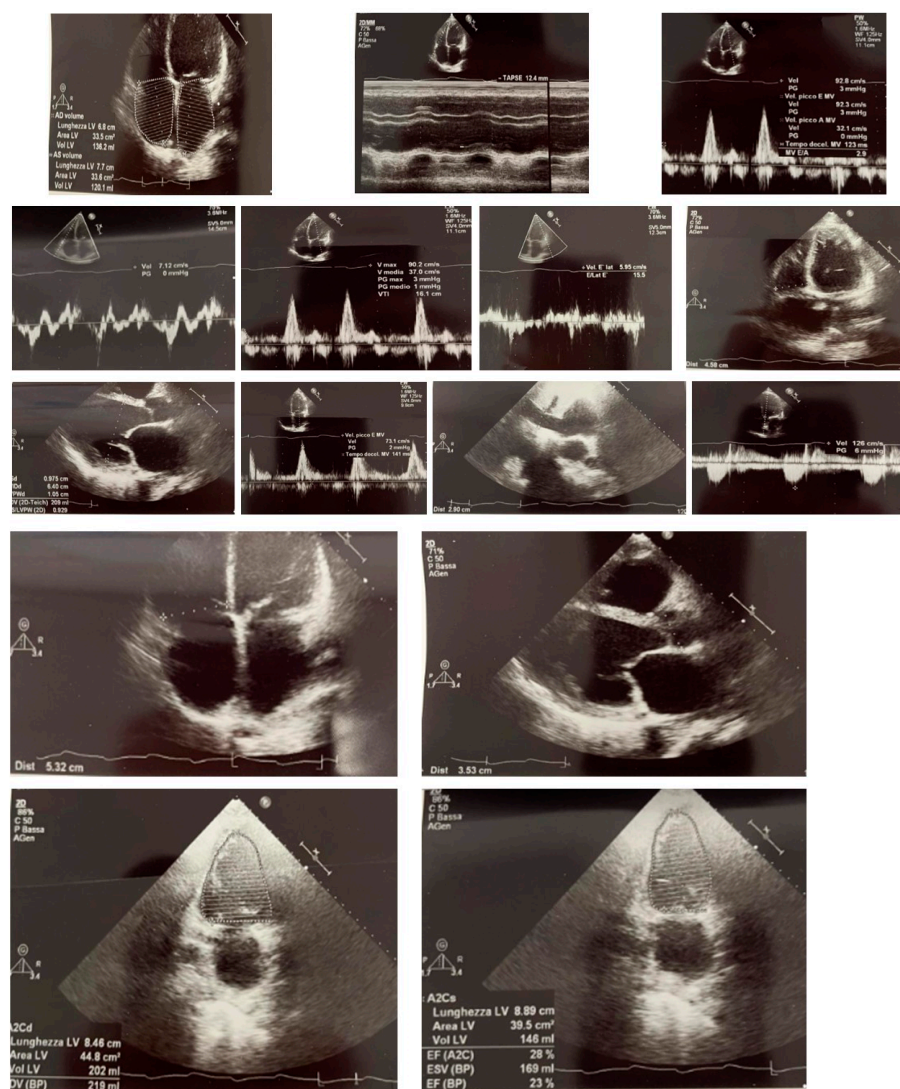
Echocardiographic picture of the patient. Detailed explanations are provided in the main text.
